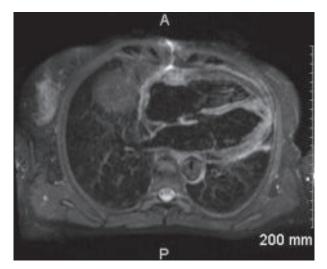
Cardiac MRI after 4 cures of chemotherapy.
